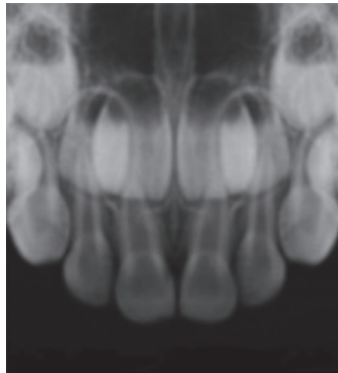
Concussion of tooth 51. No abnormal changes are seen in the radiography.
